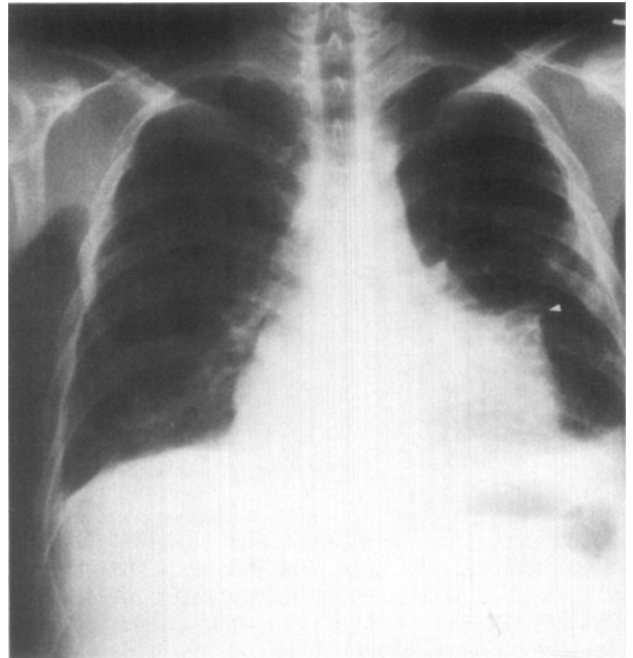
Chest x-ray. Posteroanterior view showing cardiomegaly with "tenting" (arrowhead) of the left cardiac border.
